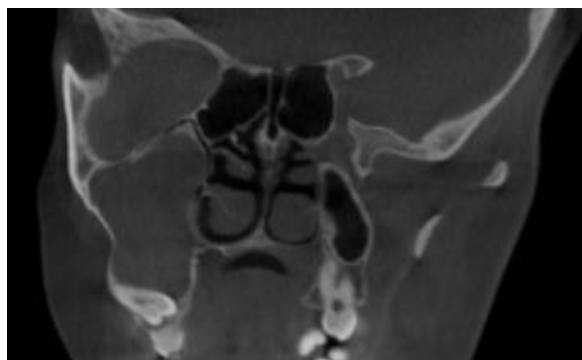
Sagittal CBCT section of the maxilla showing vertically impacted tooth 13 with its crown at the apical third of 53, an associated dentigerous cyst, and apical dilaceration
